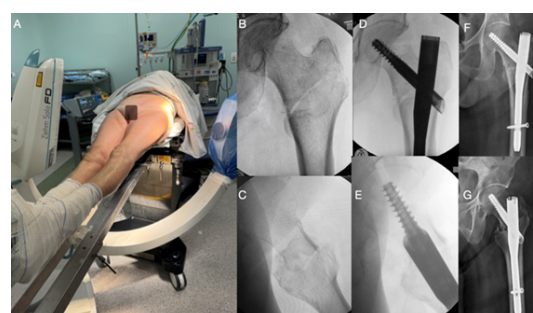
(A) Preoperative photograph of the operating room setup showing the postless technique, with the limbs in scissors and the torso in a banana-shaped position. (B and C) Intraoperative fluoroscopic images in anteroposterior and lateral views demonstrating fracture reduction achieved through traction and internal rotation of the affected limb using the postless technique. (D and E) Immediate postoperative fluoroscopic images showing fixation with a short cephalomedullary nail. (F and G) Anteroposterior and lateral radiographs obtained 30 days postoperatively, demonstrating maintained fracture reduction and proper implant positioning.
